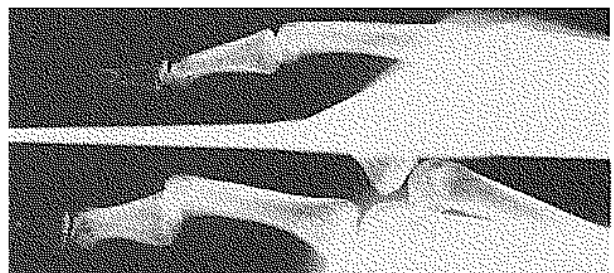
Radiograph of case 1.
